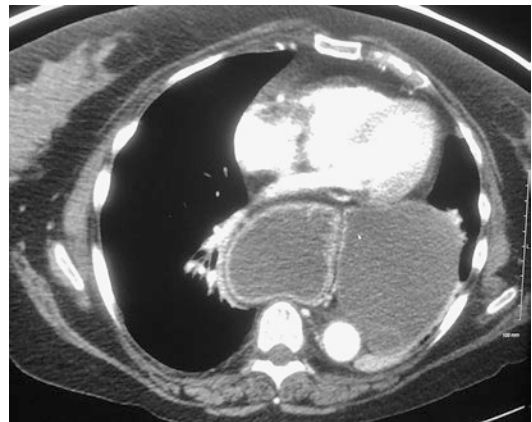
Axial CT scan of the chest demonstrating cardiac compression from a large paraesophageal hernia
